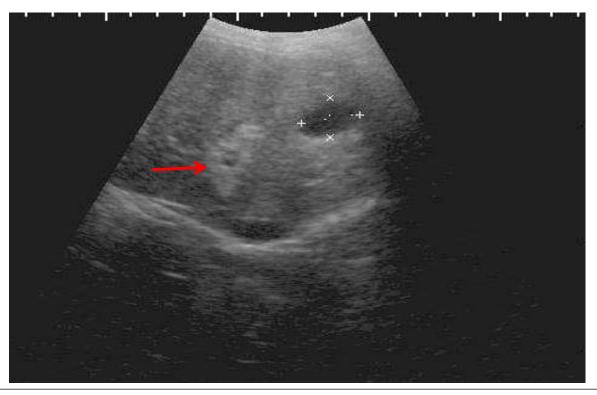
11): Ultrasonography of the first at 4th post – operative week shows heterogeneous and mottled appearance of the liver (red arrow)
